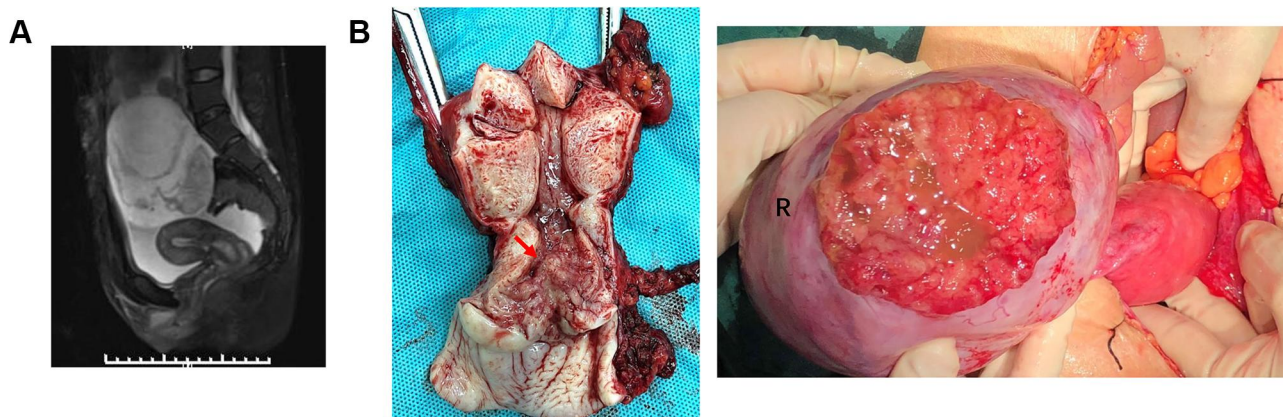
Ovarian involvement associated with the cervical adenocarcinomatous lesion. (A) Computed tomography depicting the pelvic lesion with a solid-cystic appearance. (B) The cervix and right ovary during surgery.
